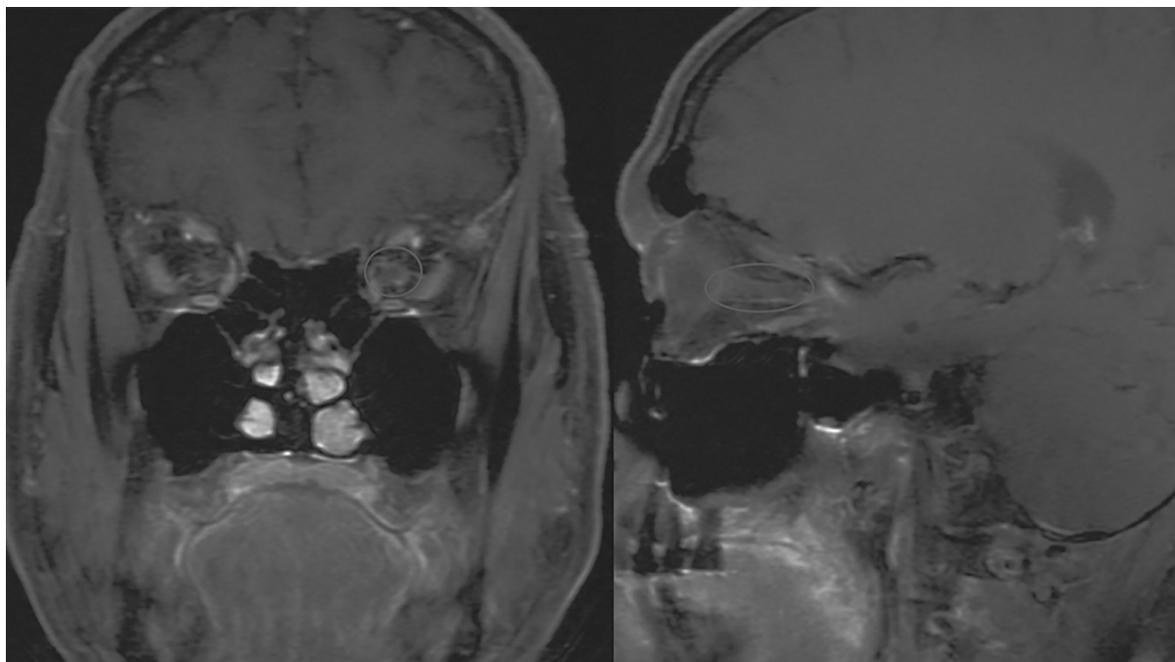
MRI brain and orbital T1 postcontrast images show left optic nerve and optic nerve sheath enhancement.
